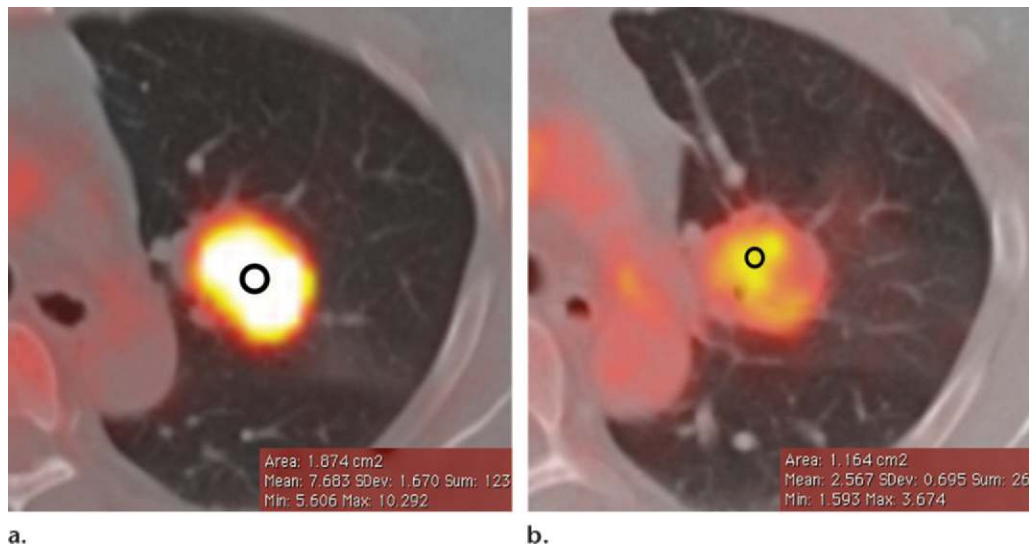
Fused PET/CT images of a left suprahilar non-small cell lung carcinoma in a 68-year-old woman. (a) Preablation image demonstrates a mean SUV of 7.7 in the region of interest (circle). (b) Image obtained after ablation shows a drop in SUV centrally, but there is an area of high SUV measuring 1.6 at the medial periphery, a finding that is suggestive of residual tumor and inadequate ablation.
